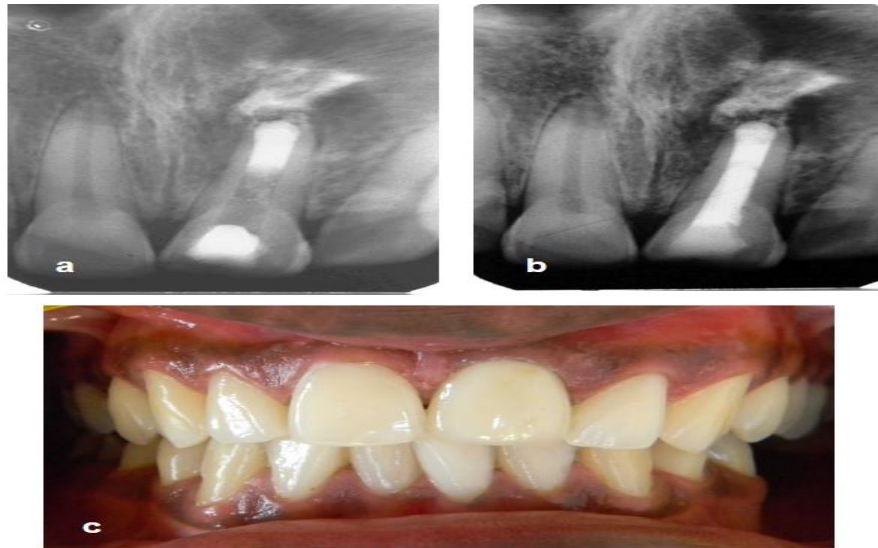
Radiograph showing (a) apical MTA plug and extrusion of MTA into the periapical lesion during the one-step apexification; (b) obturation with gutta percha using roll cone technique; (c) postoperative intra oral view of metal ceramic crown on 21
